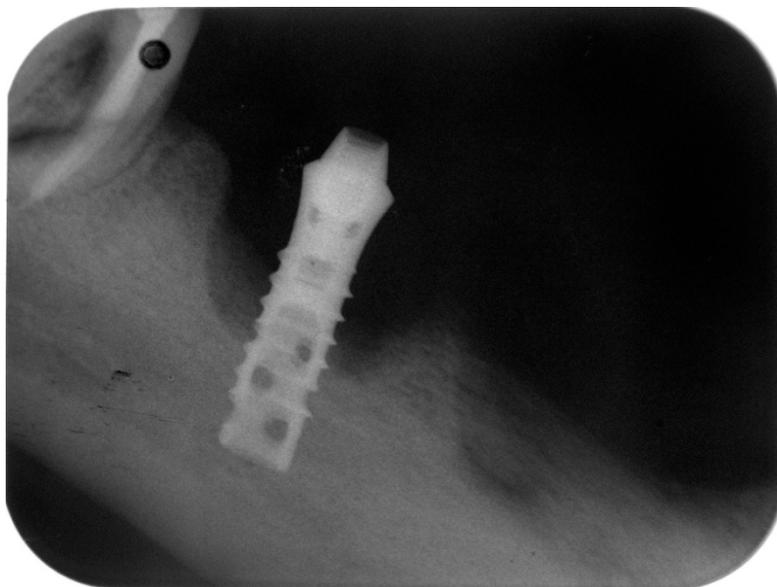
Radiographic view of a hollow-screw implant presenting excessive crater-like bone loss.
